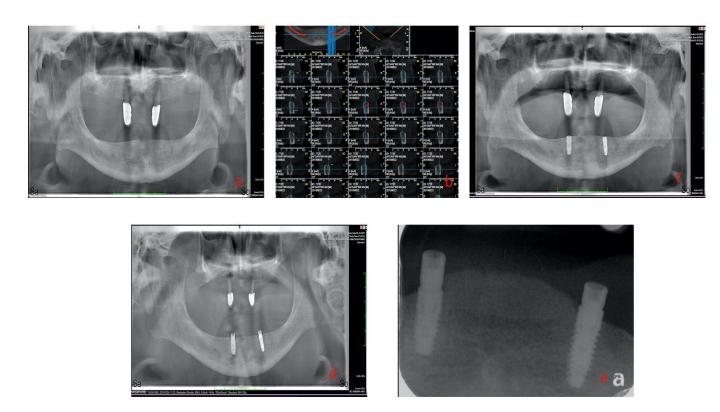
a) Preoperative radiographic image, b) Preoperative cone beam computed tomography cross-section images, c) Thirdmonth image after dental implant placement, d) Radiographic image at the stage of delivery of the prosthesis to the patient after the second implant placement surgery, e) Periapical radiograph image after two years follow-up.
